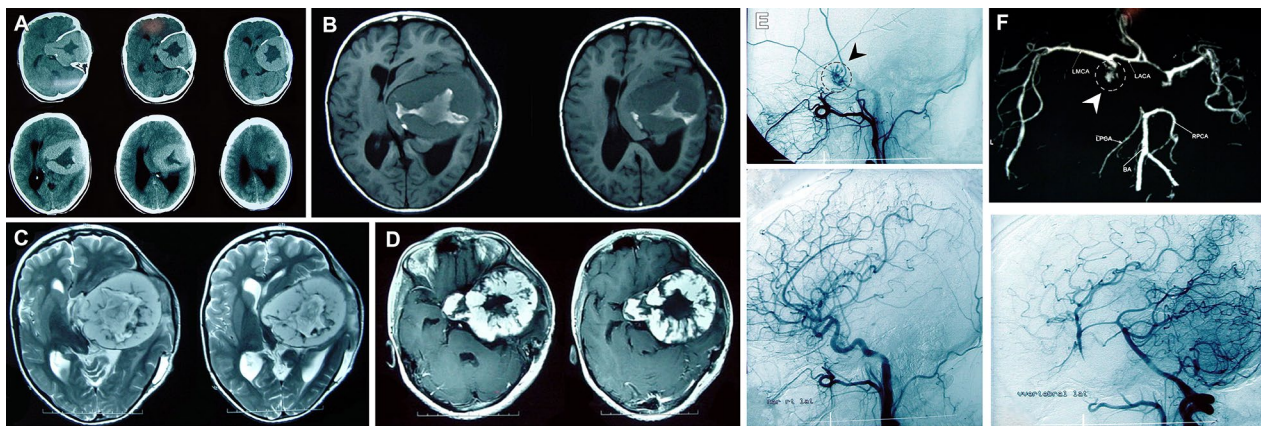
Preoperative computed tomography imaging with previous craniotomy evident laterally (A). The lesion exhibited isointense signal on T1W (B) and hyperintensity on T2W (C), with a central necrotic core with a dark, hypointense signal. A sponge-like lobulated well-demarcated lesion with heterogeneous enhancement was seen in T2-weighted (C) and gadolinium-enhanced T1-weighted (D) images. Computed tomography angiography prior to surgical intervention (F) revealed diminished-to-no arterial feeding (top right corner—dashed line and arrow head). Postoperative digital subtraction angiography (E) revealed a faint blushing of the left middle meningeal artery (dashed lines and arrow heads) and closure of the ipsilateral internal carotid following clipping. Contralateral and vertebral views are given below the image as reference
